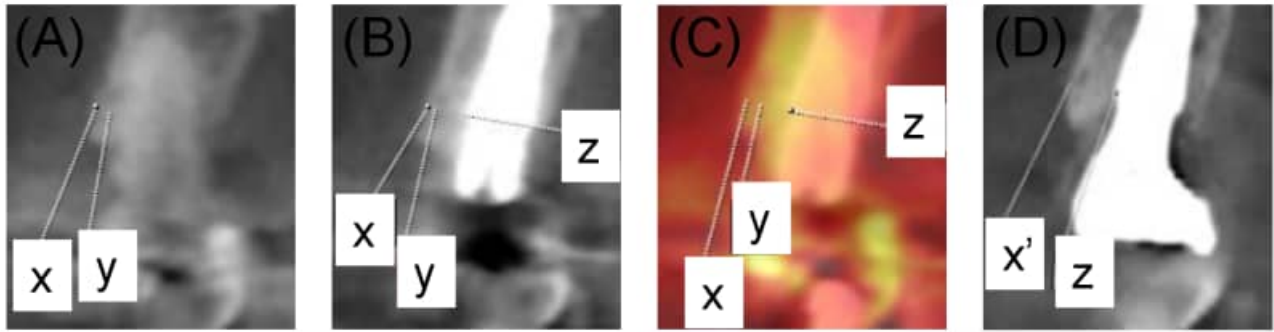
Cone-beam computed tomographic images and measurement methods at three time points: preoperative (T0), immediate postoperative (T1), and post-loading (T2). (A) Buccal bone wall thickness at T0: distance from x to y. (B) Buccal bone wall thickness at T1: distance from x to z. (C) Superimposed images of T0 and T1: gap distance between the implant and buccal wall, calculated by subtracting buccal bone thickness at T0 from that at T1. (D) Buccal bone wall thickness at T2: distance from x' to z. x, point where the line perpendicular to the implant's long axis at the implant shoulder level meets the outer boundary of the buccal bone at T1; y, point where the line perpendicular to the implant's long axis at the implant shoulder level meets the buccal border of the tooth root in the superimposed images of T0 and T1; z, point where the line perpendicular to the implant's long axis at the implant shoulder level meets the buccal border of the tooth root in the superimposed images of T0 and T1; x', point where the line perpendicular to the implant's long axis at the implant shoulder level meets the outer border of the buccal bone at T2.
